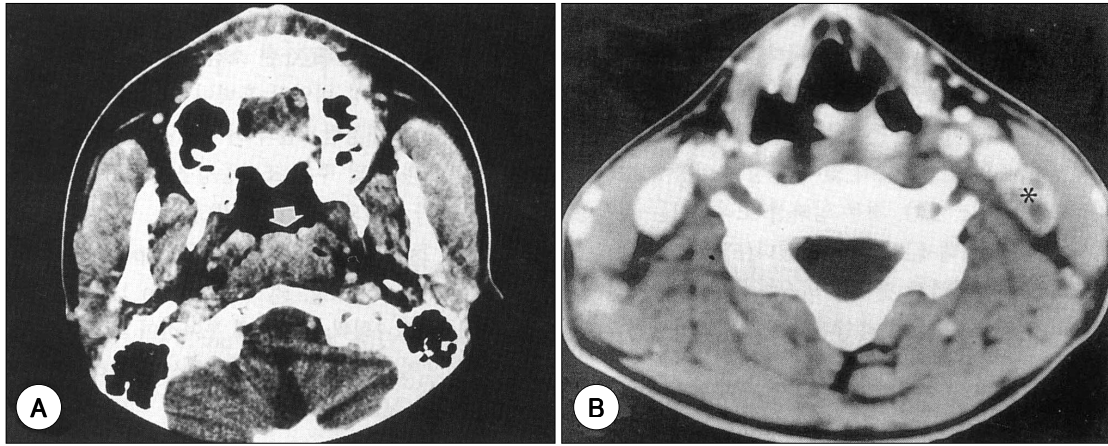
CT findings. A : The pharynx CT shows diffuse thickening of posterior nasopharyngeal wall (arrow). B : The neck CT shows multiple conglomerated, ring enhanced necrotic lymph nodes enlargement along left internal jugular chain (*).
